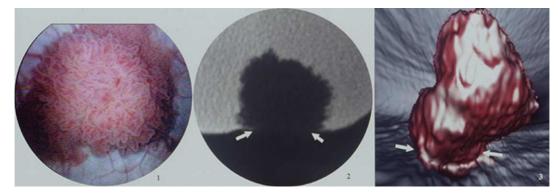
Typical papilloma: 3-D CT cystoscopy (right image), axial-CT section (middle image) and cystoscopy (left image) show a large villous papillary tumor (sea anemone-like tumor) with numerous short folds and quite large base proven to be a T1 stage (courtesy of R. Palau [50]).
